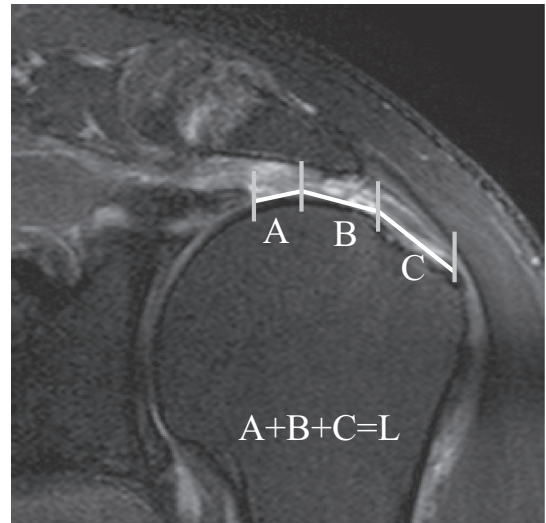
Measurement of the rotator cuff tear length. The rotator cuff tear length (L) is evaluated using up to three linear distance measurements that acceptably approximated the curved articular surface of the humeral head on MR images.
